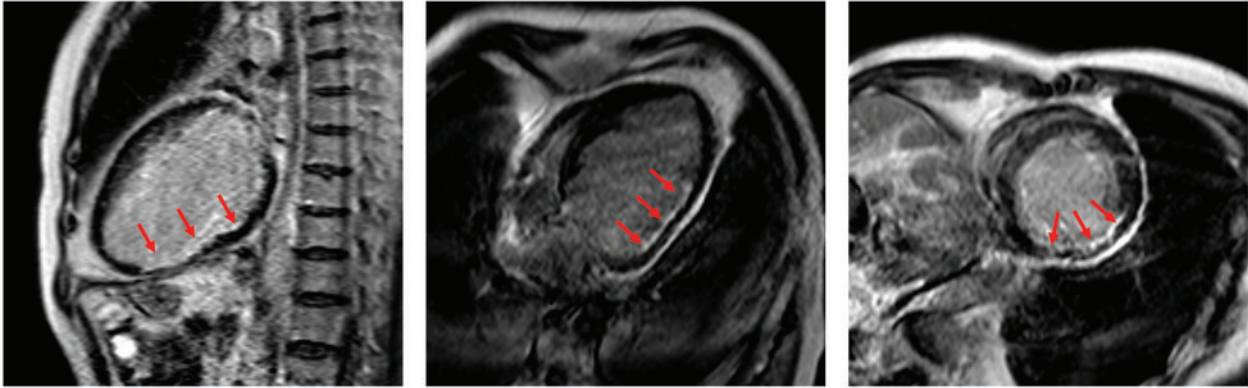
Late gadolinium-enhanced magnetic resonance imaging shows subendocardial infarction in the inferior wall and posterior wall (red arrows).
